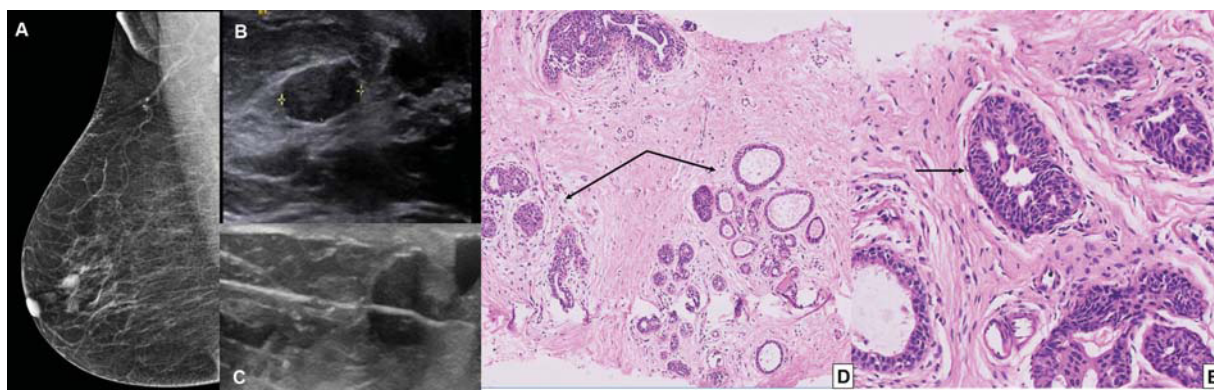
A 65-year-old female with a history of carcinoma colon, on follow up, for screening mammogram. The Mammogram showed an oval circumscribed equal density lesion noted in the subareolar region of the right breast. Ultrasound shows oval circumscribed hypoechoic lesion which appears soft on elastography—BIRADS III lesion but the patient was anxious and wanted a biopsy. Corresponding pathological image (A) shows breast parenchyma with dilated ductal lobular units with areas of fibrosis and adenosis (arrow) and image (B, C) shows the glandular elements show evidence of usual ductal hyperplasia (D, E; arrow). BIRADS, Breast Imaging Reporting and Data System.
